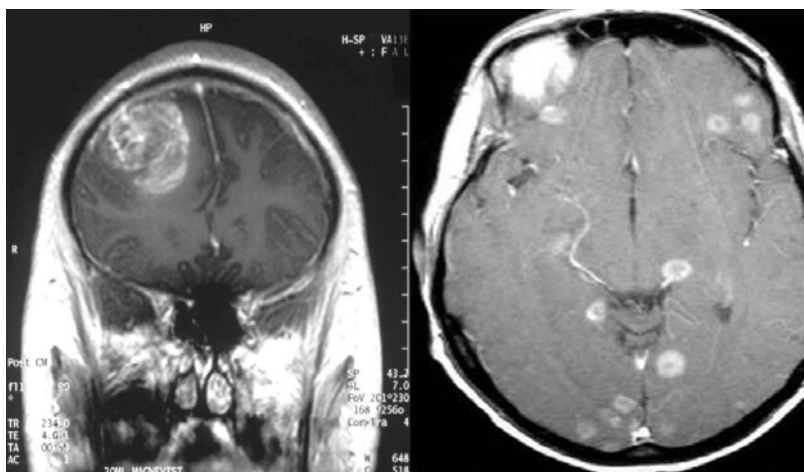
CT scans of a grade IV glioma (*left*) and intracranial metastases of a primarily invasive breast cancer (*right*) are shown. Notably, the locally infiltrative growth of a grade IV astrocytoma leads to pronounced mid-line dislocation, while the multiplex metastases of a primarily infiltrative breast cancer are well confined.
